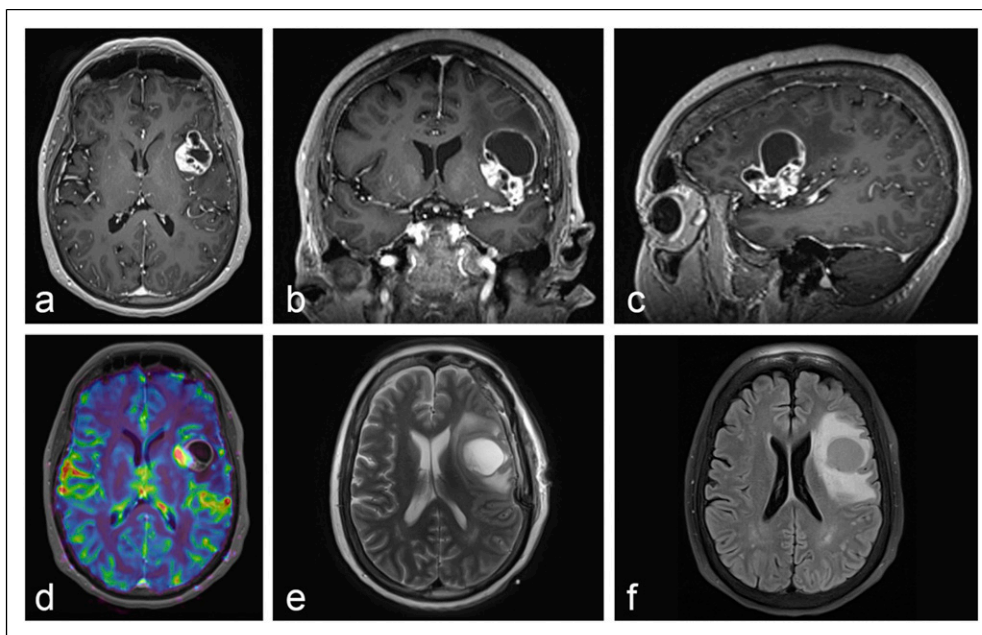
Initial MRI of the Brain. (a–c) T1-weighted imaging with a heterogeneously enhancing lesion of the left insular cortex with a large cystic component extending superiorly into the left inferior frontal gyrus with significant surrounding vasogenic edema. (d) Perfusion-weighted imaging with metabolically active tumor within the left insular cortex. (e) T2-weighted imaging with a moderately-sized cystic component extending superiorly into the left inferior frontal gyrus. (f) Fluid-attenuated inversion recovery imaging confirming vasogenic edema surrounding the tumor of the left insular cortex and cystic component.
